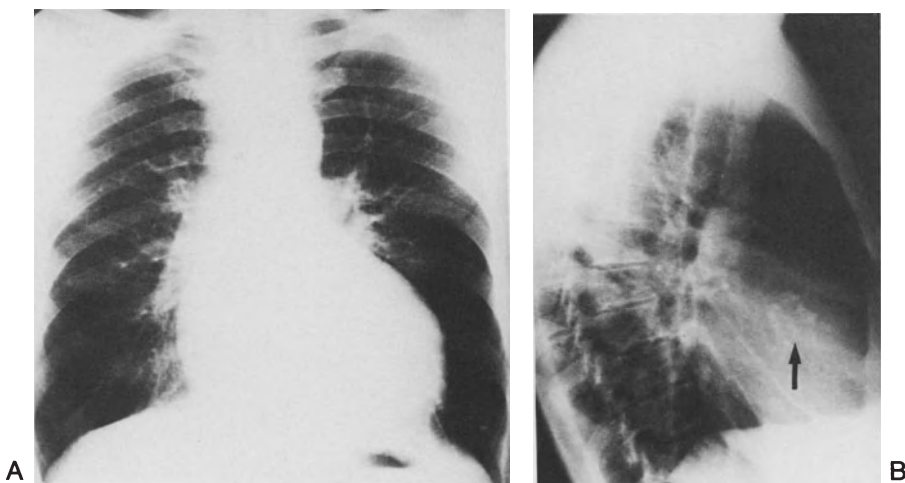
The X-rays in calcific aortic stenosis demonstrating enlargement of the ascending aorta and left ventricular hypertrophy in the frontal view
